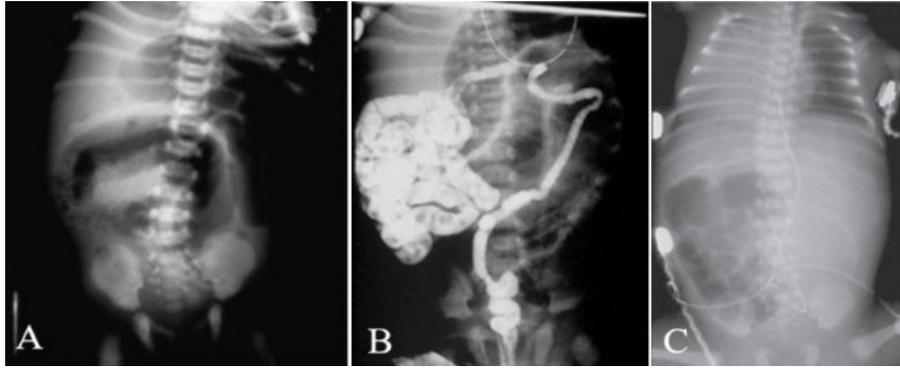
A: A: Plain abdominal X-ray, large air images.
